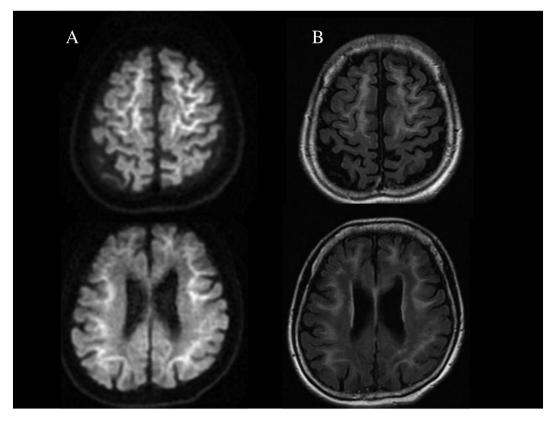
Brain magnetic resonance imaging: diffusion weighted image (A) and fluid attenuated inversion recovery image (B). Slight brain atrophy is observed along with linear hyperintensities at the corticomedullary junction of the frontal and parietal lobes.
